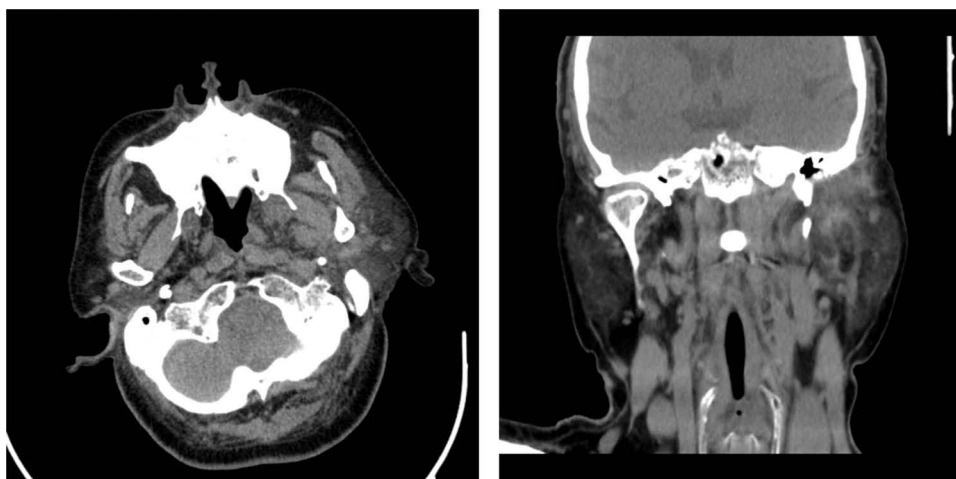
Facial enhancement CT.
